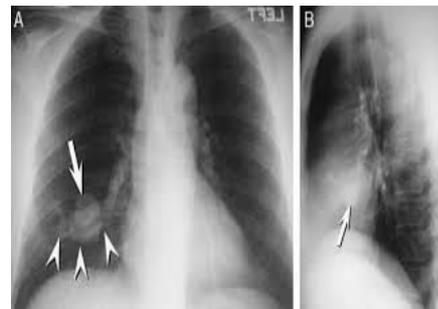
This radiographic image shows a coin lesion (Hamartoma)
